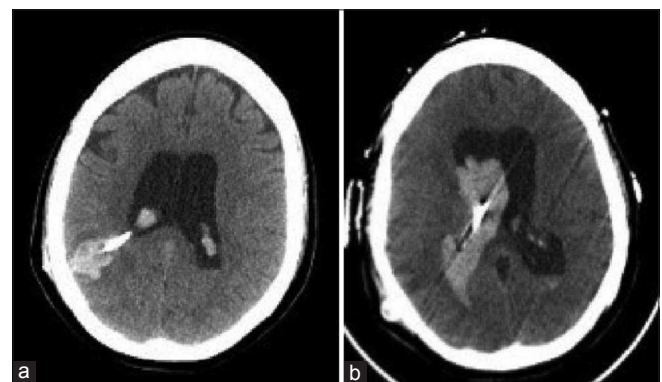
Noncontrast computed tomography, axial view showing (a) right parietal intraparenchymal hemorrhage along tract of the right parietal ventriculostomy catheter, as well as (b) intraventricular hemorrhage and associated hydrocephalus.
